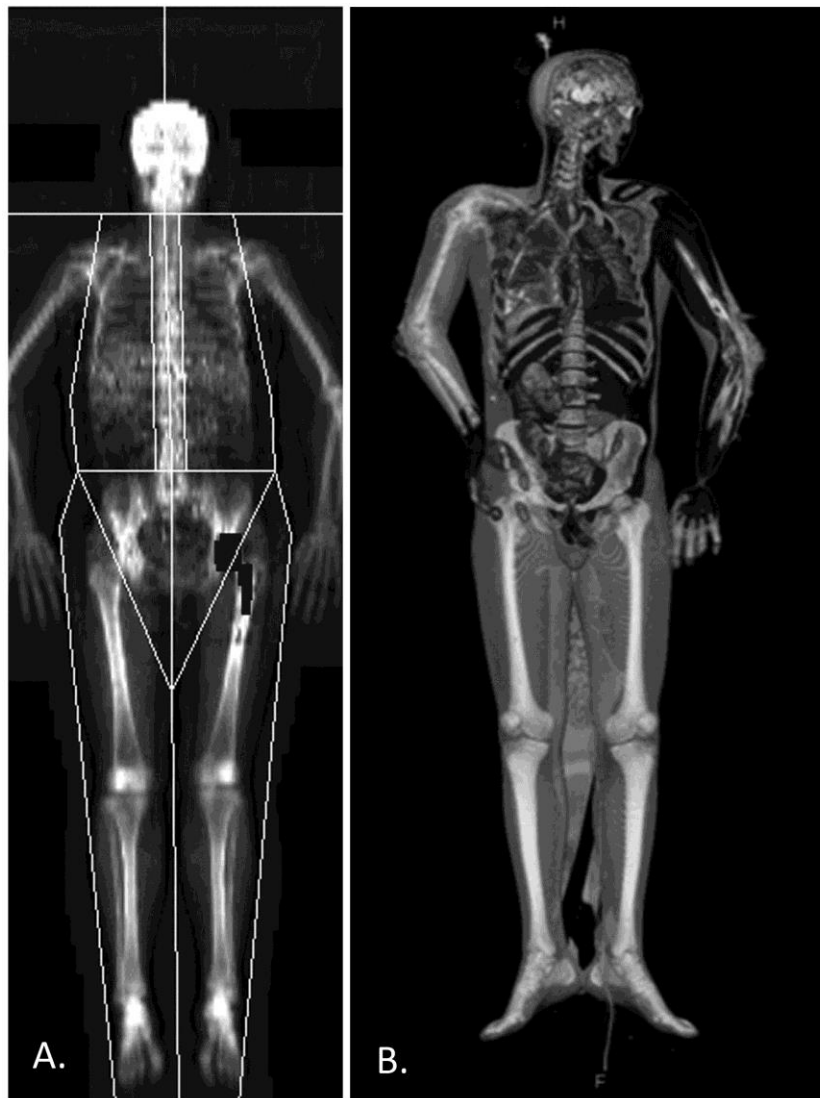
Representative images from clinical whole body scanners. A. DXA scan - notice 2D image superimposes sternum, ribs, and digestion organs over vertebral column. Subject is also post left hip replacement. B. CT scan – 3D imaging allows individual analysis of each skeletal site as well as separation of cancellous bone from cortical bone.
